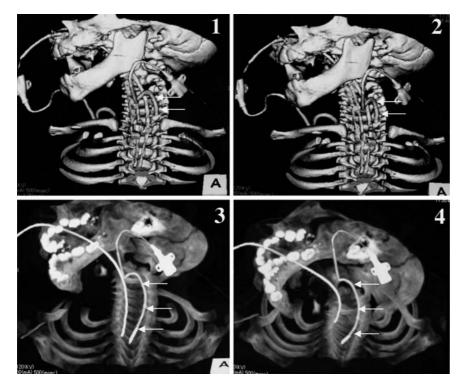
Three-dimensional computed tomography of the neck. The left side of each image is the anatomic right. Images I and 2 show that the catheter is advancing in the C6-C7 intervertebral foramen (shown by *white arrows*). Images 3 and 4 show that the catheter has advanced counterclockwise to the back of the spinal cord in the intrathecal space (shown by *white arrows*). An endotracheal tube proceeds from the right nostril into the trachea
